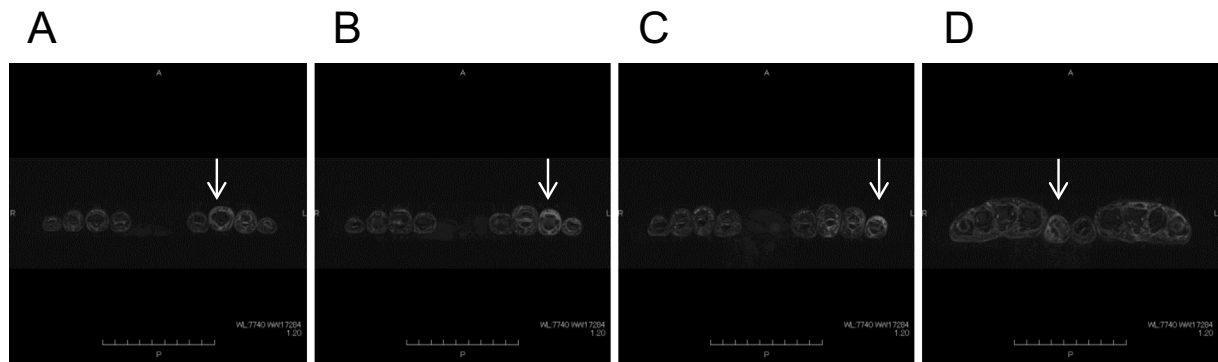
Short-tau inversion-recovery (STIR) magnetic resonance imaging (MRI) showed high-intensity signals for the tenosynovium of the left third (A, arrow), fourth (B, arrow), and fifth fingers (C, arrow) and the right first finger (D, arrow).
